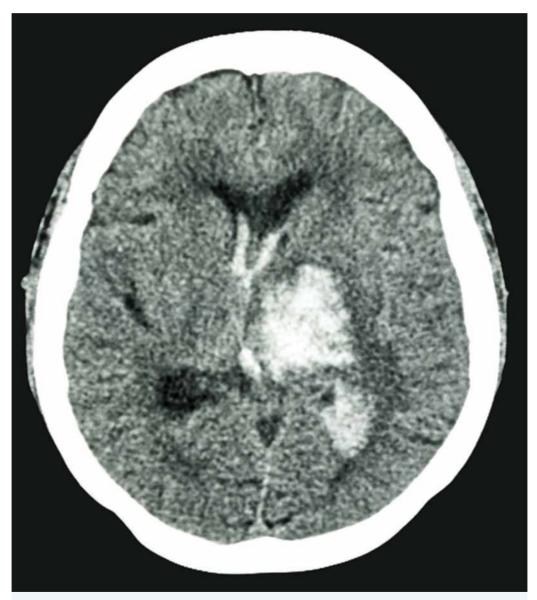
A stroke is the leading cause of acquired brain injury in Australia. The white area towards the centre of this CT scan shows brain damage caused by a burst aneurysm which is a common cause of a haemorrhagic stroke. An aneurism is a weak or thin spot in the wall of an artery that has swelled and ballooned out. As the aneurysm gets bigger, it becomes thinner and weaker and often will leak or burst, which releases blood into the brain.
